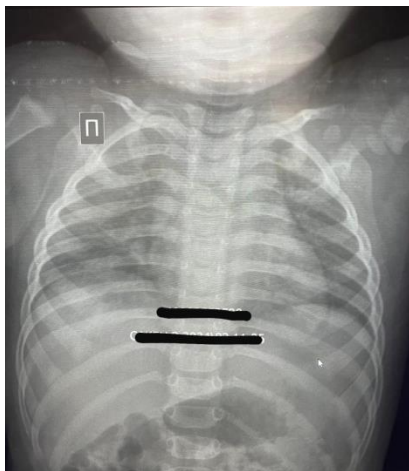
In Patient No. 2, no radiographic evidence of pneumonia was observed on the chest radiograph on day 1 of illness.
